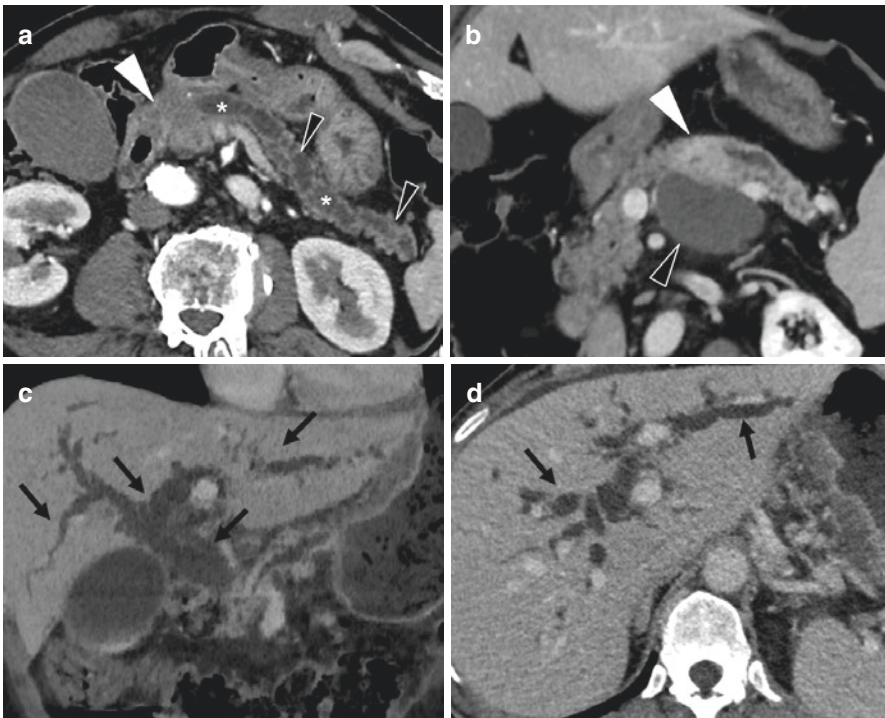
Indirect CT signs of pancreatic adenocarcinoma. CT with contrast injection, axial views (a and d), coronal view (b), and coronal reconstruction with MinIP (c) showing the various indirect signs of pancreatic adenocarcinoma: Dilatation of the main pancreatic duct (asterisks) and parenchymal atrophy (black arrowheads) upstream from a tumor in the pancreatic isthmus (white arrowhead) (a). Dilatation of the intrahepatic and extrahepatic bile ducts (black arrows) upstream from a tumor in the pancreatic head (c and d). Retentive pseudocyst (black arrowhead) upstream from an isoattenuating tumor in the pancreatic head (white arrowhead) (b)
